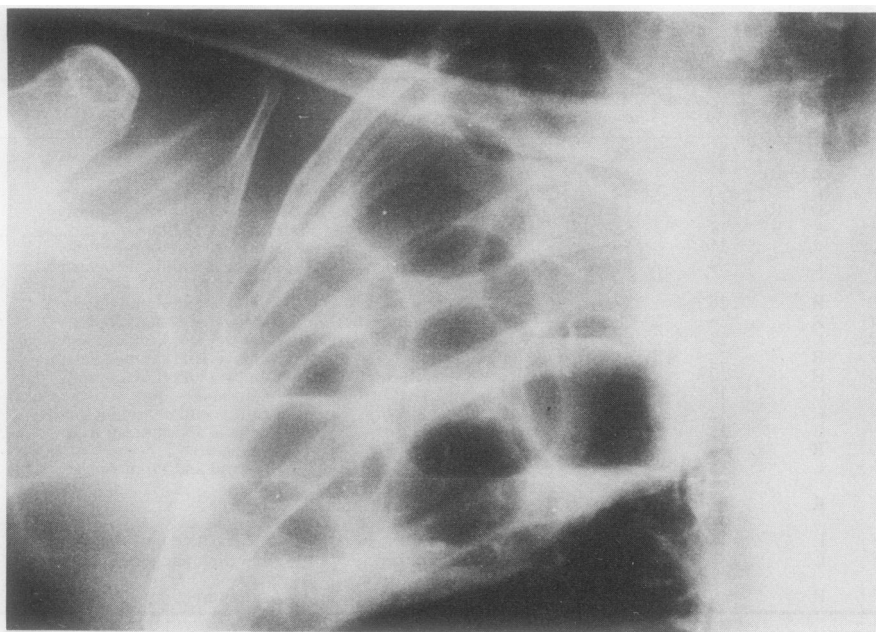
Case 2: Apical radiograph of 15 lucite spheres associated with tuberculous infection 30 years after insertion. One sphere has eroded almost through the chest wall.*
